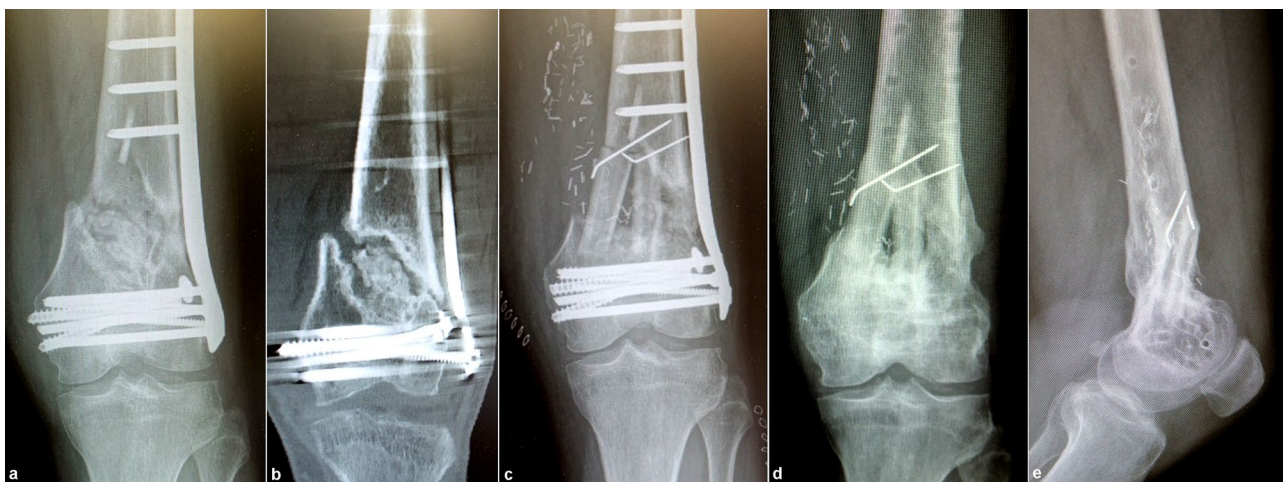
A 59-years-old male patient with a supracondylar distal femoral fracture. X-rays (a and b) non-union after treating by a locking plate osteosynthesis; (c) result after 3 months; (d and e) result at 24 months
